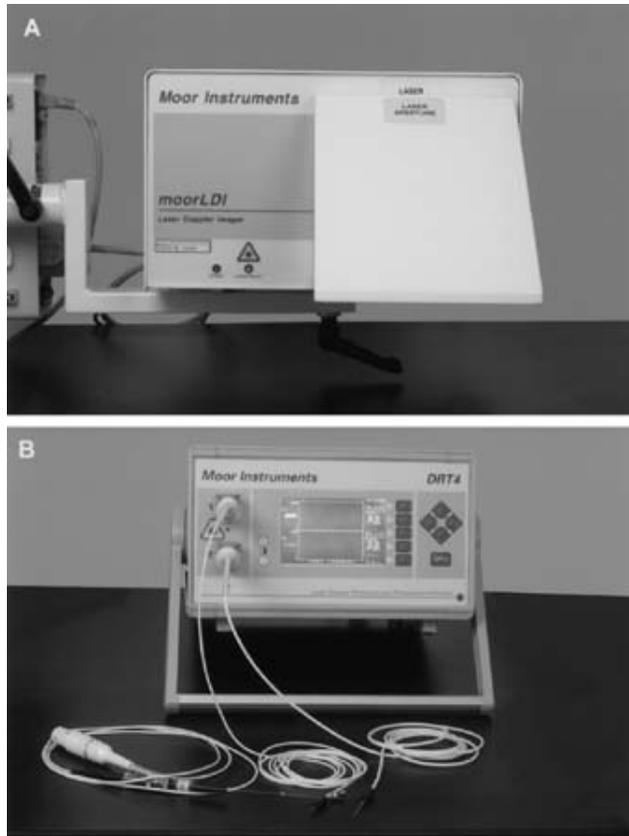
Laser Doppler instrumentation. (A) Scanning laser Doppler imager (LDI) (B) single point fiber optic monitor with fiber optic probes (LDF)
